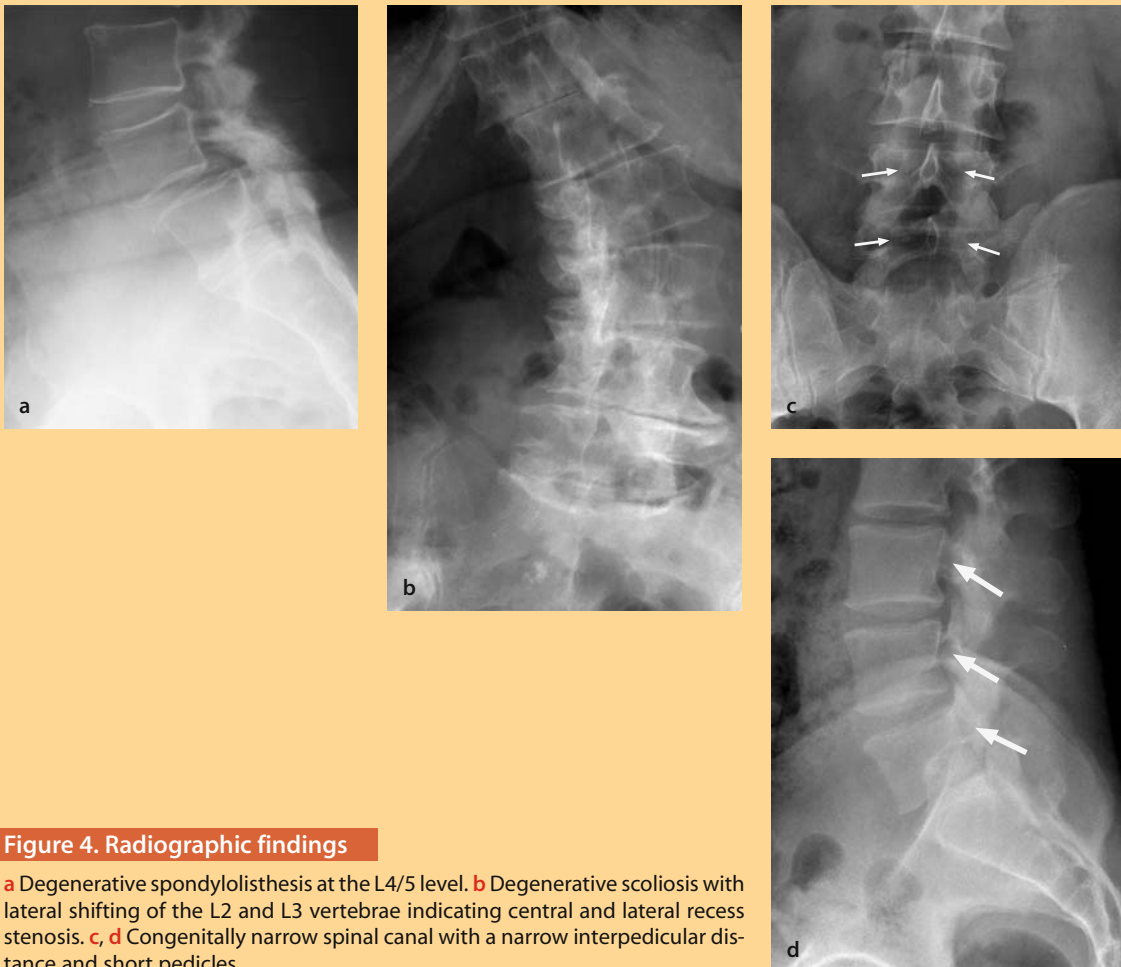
Radiographic findings
